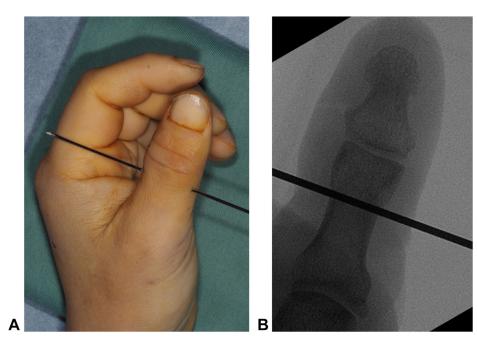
Insertion of the K-wire. An intraoperative photograph A and a posteroanterior x-ray B show that the K-wire was inserted slightly distal to the middle of the proximal phalanx.
